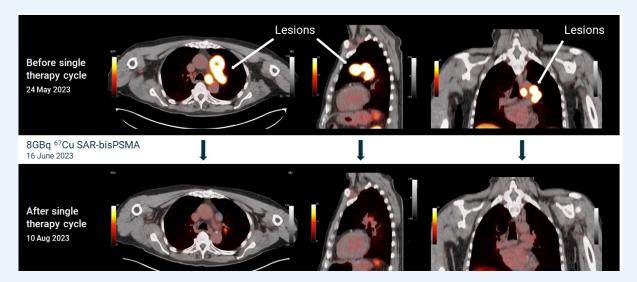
⁶⁴Cu-SAR-bisPSMA PET/CT imaging before (arrows) and after a single cycle of 8GBq ⁶⁷Cu-SAR-bisPSMA in a cohort 2 participant. Images show considerable reduction in uptake of ⁶⁴Cu-SAR-bisPSMA, as well as lesion size. Images: PET/CT fusion.
